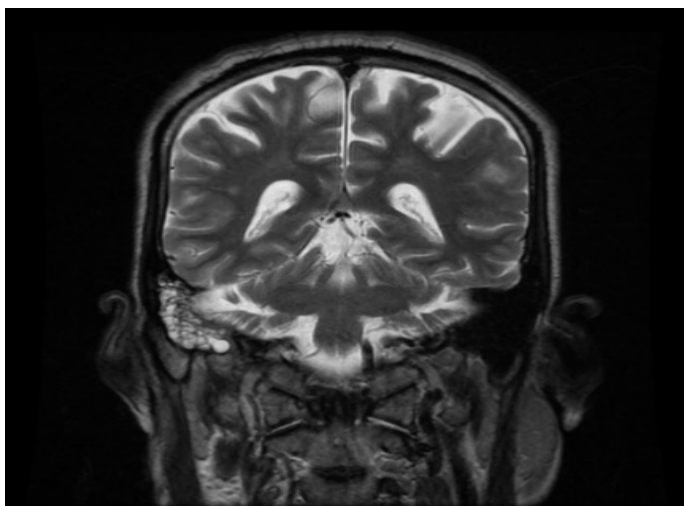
T2W MRI showing fluid in mastoid air cells suggestive of mastoiditis.
